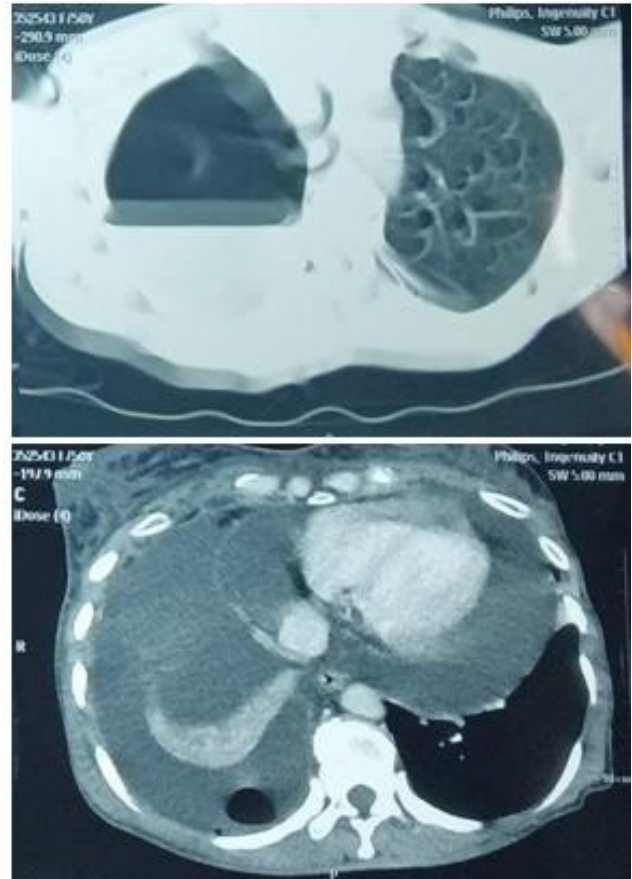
Chest CT scan showed right hydropneumothorax (a) and pericardial effusion (b).
